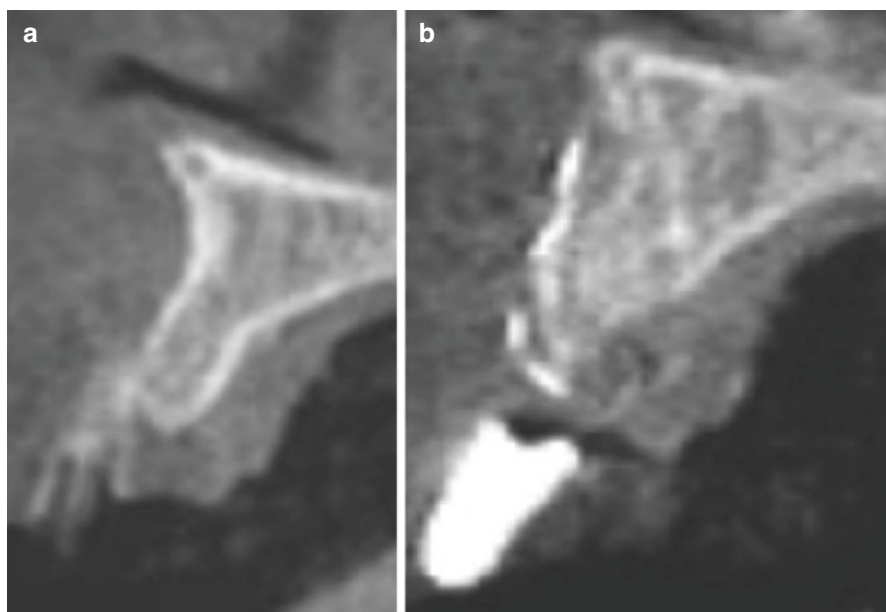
(a) Cone-beam computerized tomogram (CBCT) cross-section before ridge augmentation. (b) CBCT cross-section 6 months after lateral ridge augmentation
